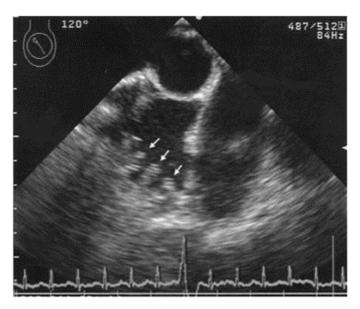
Pectinate muscles (arrows) demonstrated by transesophageal echocardiography viewed at 120°.
